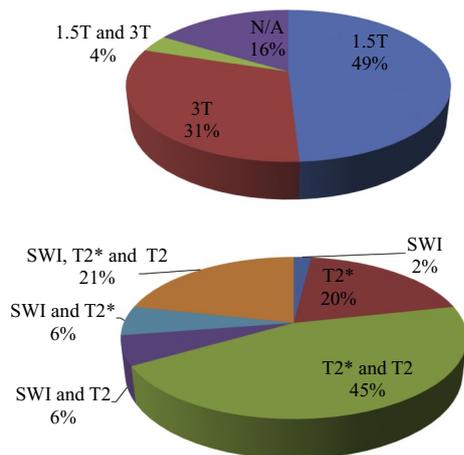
Distribution of the magnetic field strength and MRI sequence in the diagnosis of SHS at each institute. SWI, susceptibility-weighted imaging; NA, not available.
